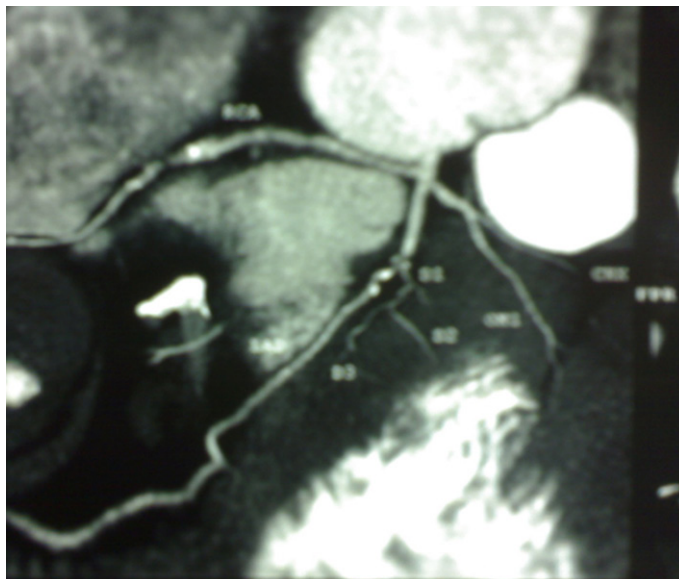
Computed tomographic(CT) angiography shows anomalous right corona artery originating from the left main coronary artery and courses between aorta and pulmonary artery.
